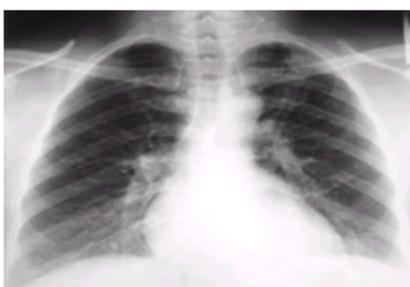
Posteroanterior chest x-ray film of case 2 reveals residual scarring in the left lung after completion of treatment.
